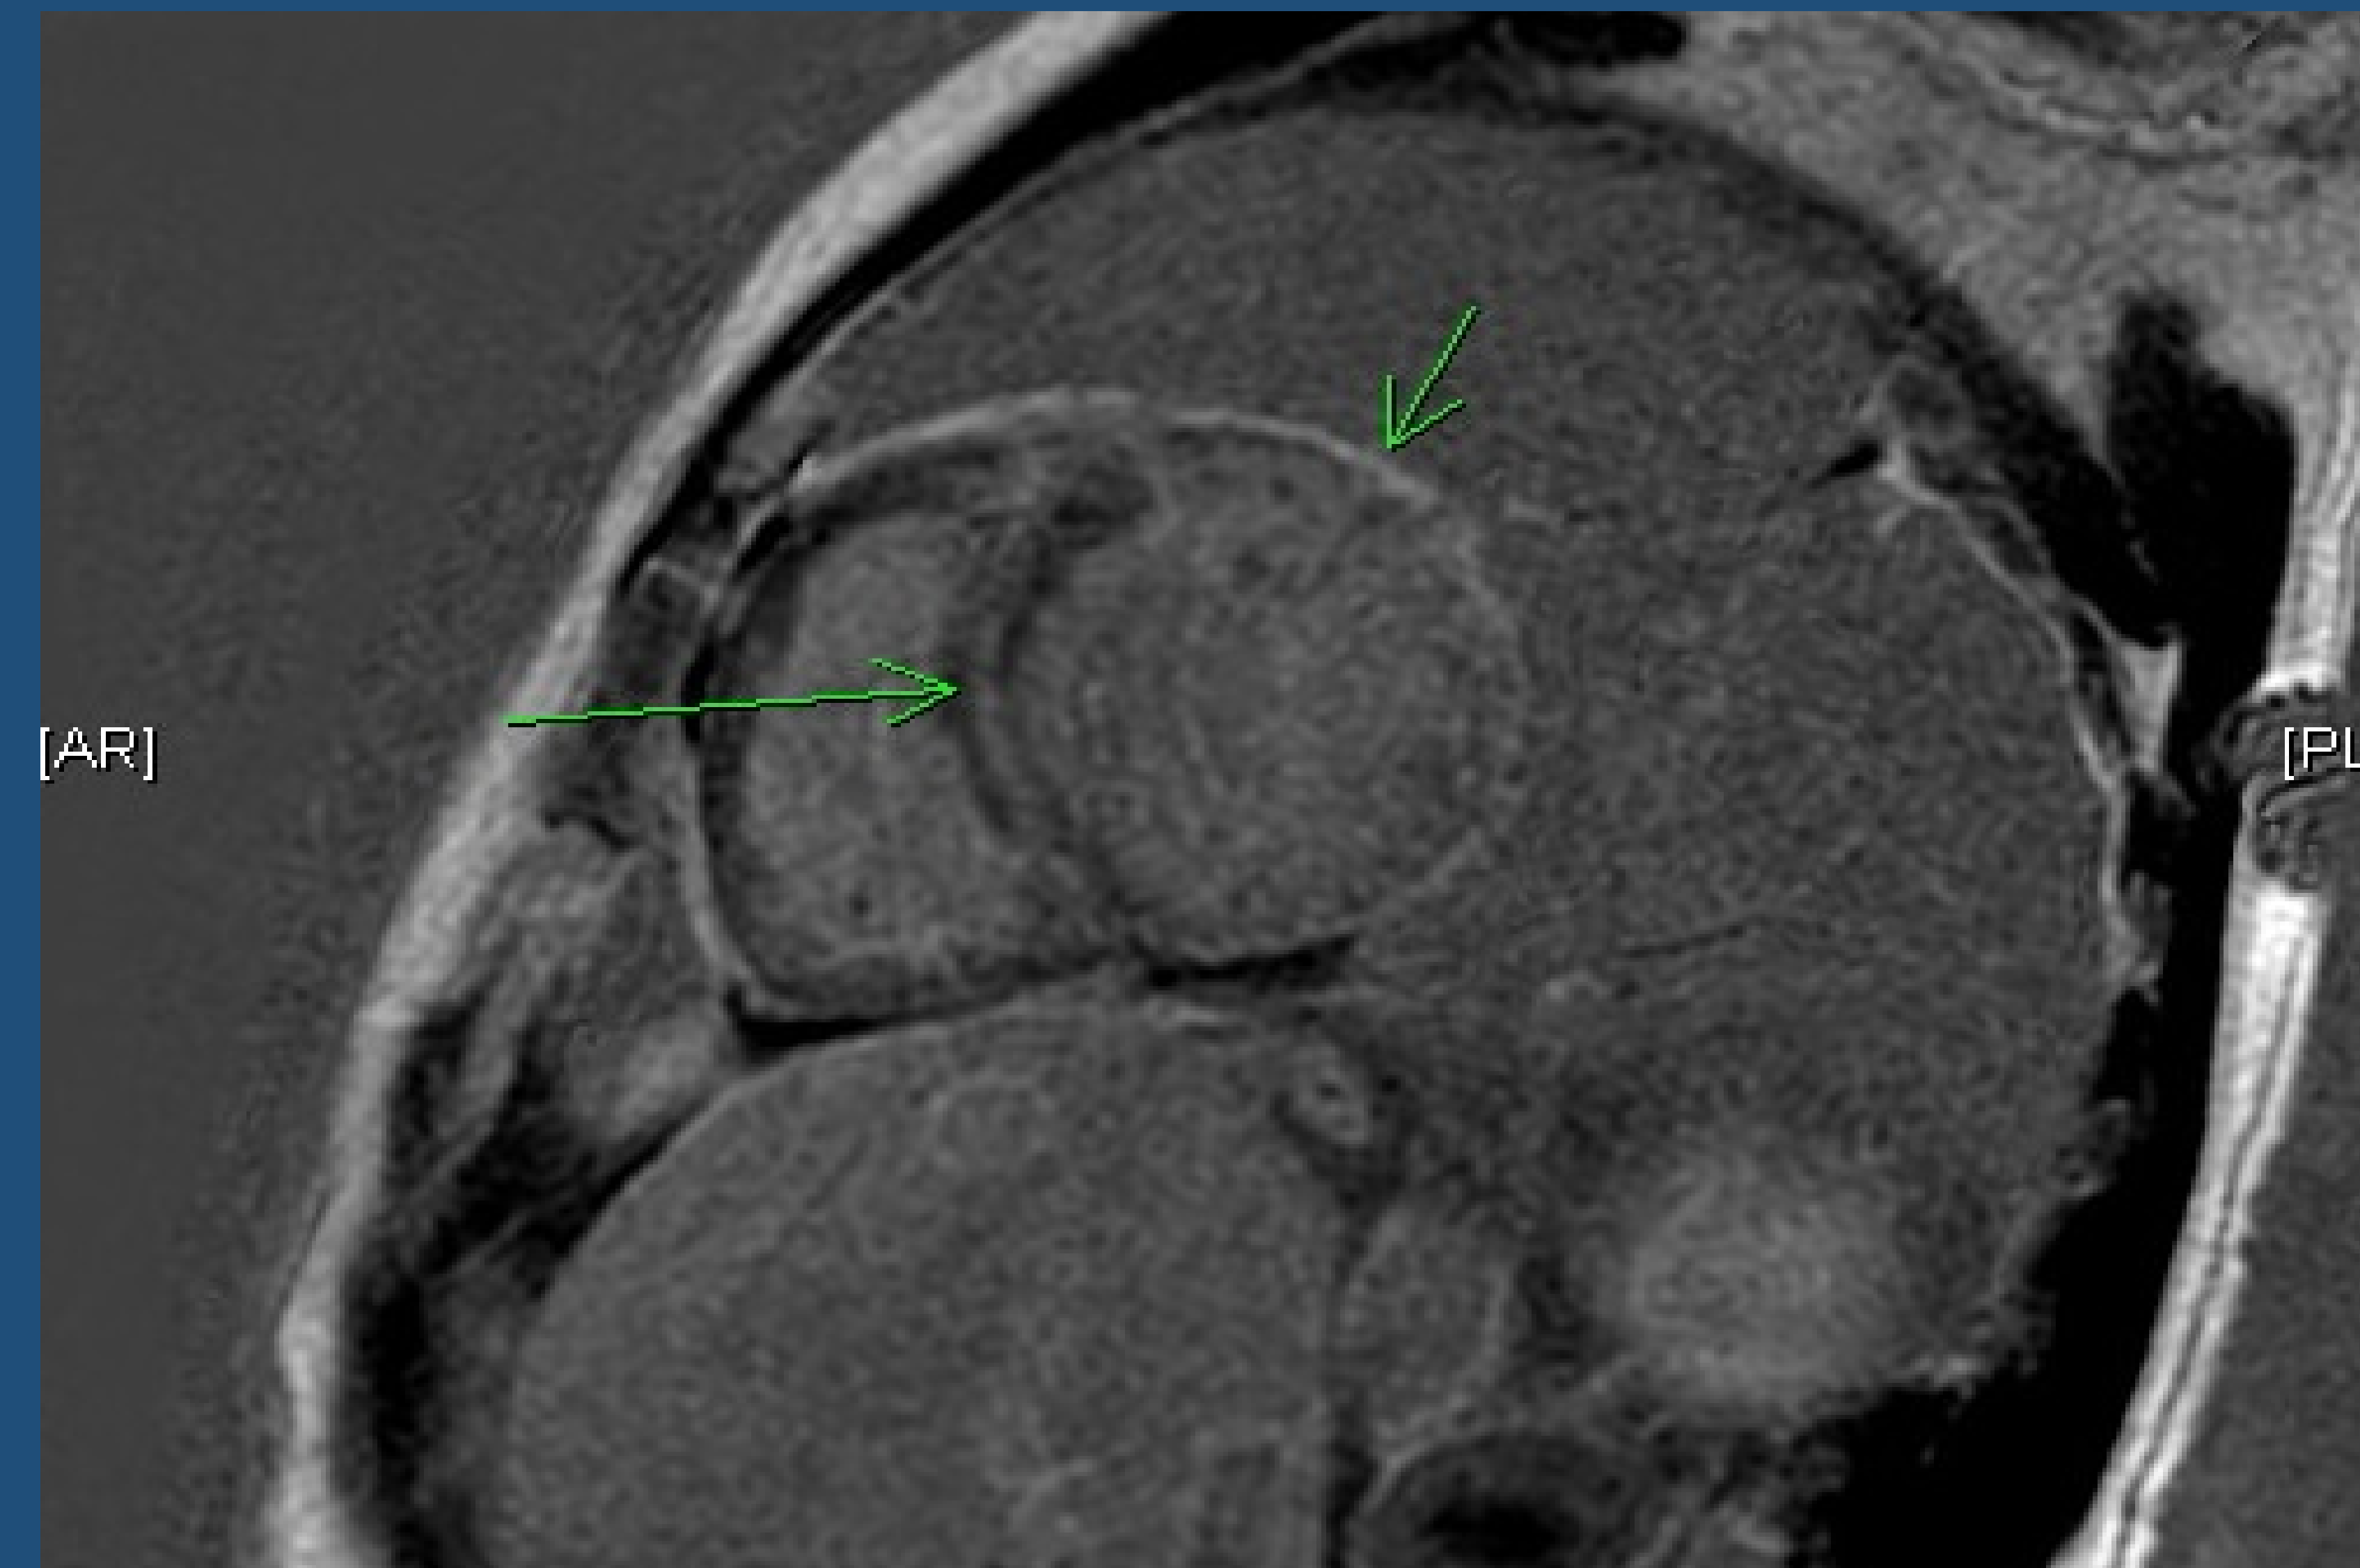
Late gadolinium enhancement of interventricular septum (large arrow) and pericardium (small arrow) seen on Cardiac MRI.
